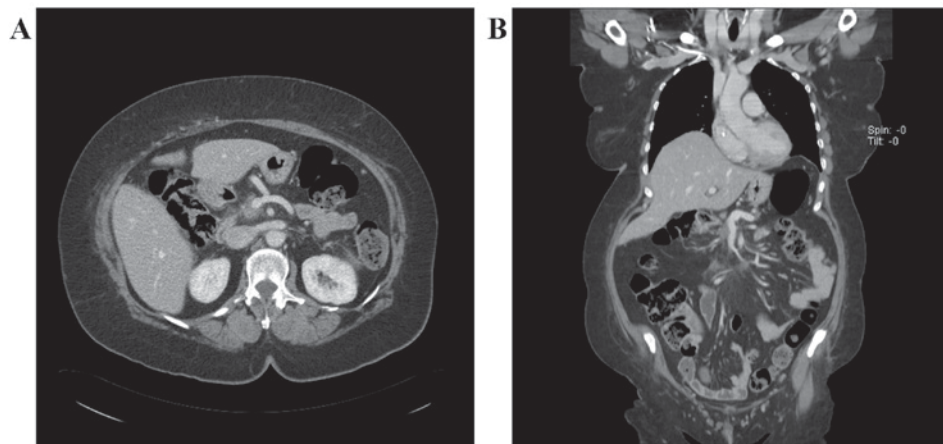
(A) Axial plane and (B) coronal plane computed tomography scan subsequent to neoadjuvant chemotherapy, showing radiological signs of the cancer's response to chemotherapy: e.g. Tumor shrinkage and recanalization of superior mesenteric vein.
